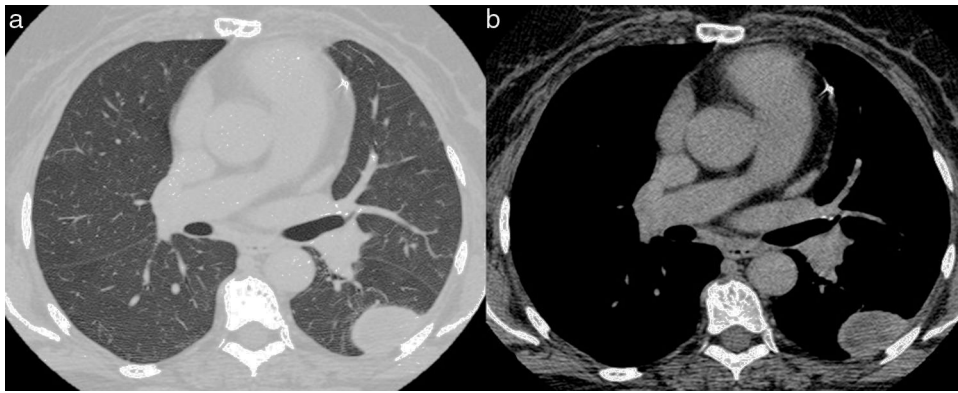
Axial chest computed tomography images obtained with the pulmonary (a) and mediastinal (b) window settings reveal a well-defined mass of probable extrapulmonary origin (the larger diameter is related to the pleural surface, and the mass, in its anterior portion, forms an obtuse angle with the chest wall), located posteriorly in the middle third of the left hemithorax, in close contact with the pleural surface.
